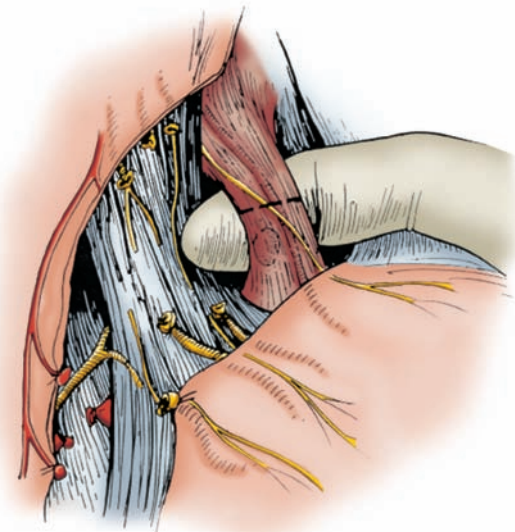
The serosa has been cut to the left of the esophagus, and fatty areolar tissue to the left of the esophagus, containing nerve fibers, blood vessels, and lymphatics, is hooked up by the right index finger. The angle of His and the adjacent esophagus with a 2- to 3-cm portion of the fundus of the stomach are thoroughly cleaned. In this way, small nerve fibers running to the proximal 3-cm portion of fundus (“criminal nerves of Grassi”) are eliminated. (Redrawn, with permission, from Johnston D. Vagotomy. In: Schwartz SI, Ellis H, eds. *Maingot's Abdominal Operations*. Norwalk, CT: Appleton-Century-Crofts; 1985. After R.N. Lane.)
